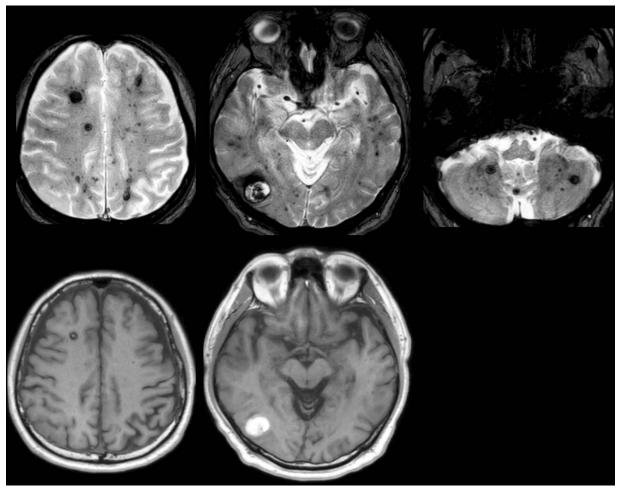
Brain magnetic resonance imaging (MRI). T2-star MRI revealed multiple micro-bleedings as low-signal spotty lesions (upper). T1-weighted MRI was used to visualize relatively new bleeding in the right occipital lobe as a high-signal lesion (lower).
